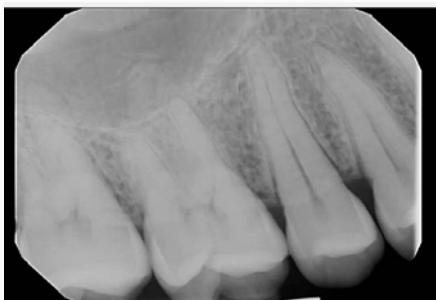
Periapical depicting vertical root fracture.
